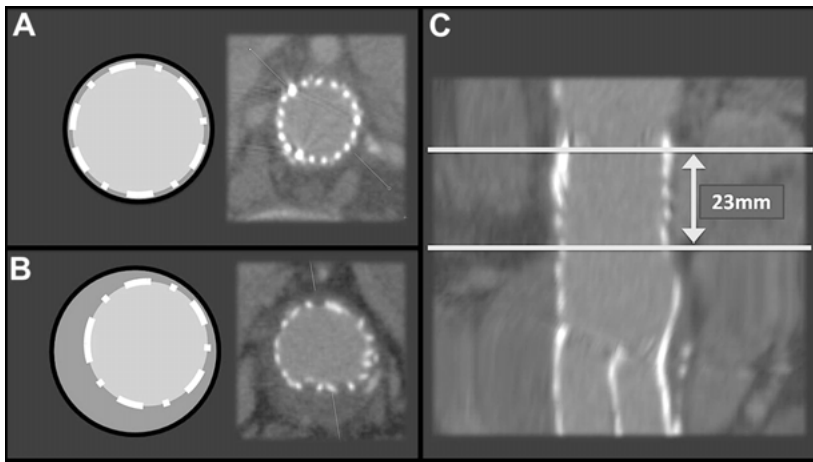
The method of measuring sealing zone on the CTA. A, Reconstructed axial slice shows adequate seal, 2 mm below the renal arteries, with good wall-graft apposition in the entire vessel circumference. B, Same patient, 30 mm below the renal arteries, shows inadequate seal. C, Length of adequate proximal seal, measured in stretched view. (Reprinted with permission from journal of vascular surgery/Elsevier) (Bastos Goncalves et al., 2013).
